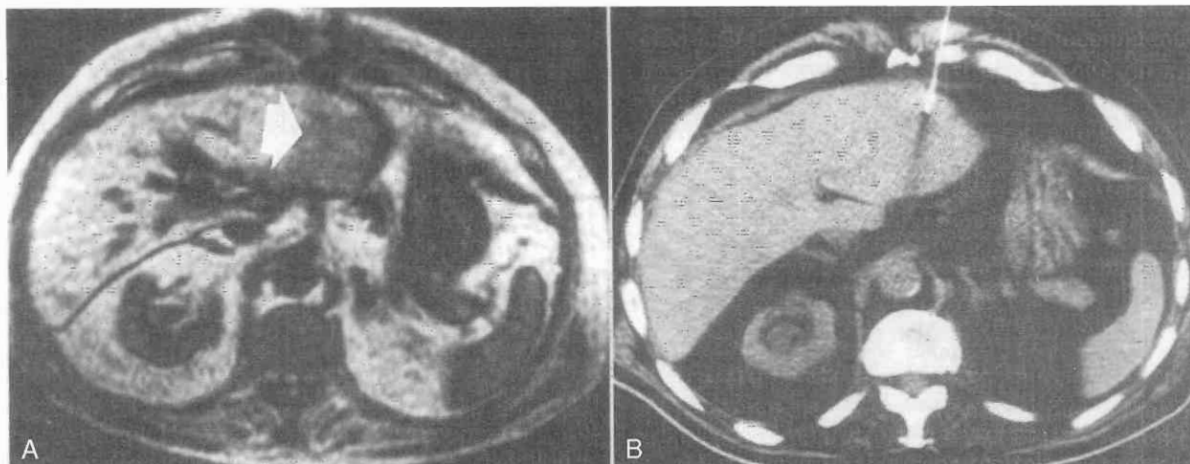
These scans show an MR-guided procedure and a CT-guided procedure of a liver lesion. A, This MR scan shows the low-intensity mass within the left lobe much more clearly than does the CT scan. The needle (arrow) is difficult to see. B, This CT scan taken at the same level shows the visualization of the needle in the same mass. With current technology, the best result in such cases is to correlate the location on the MRI scan with the CT during biopsy.
